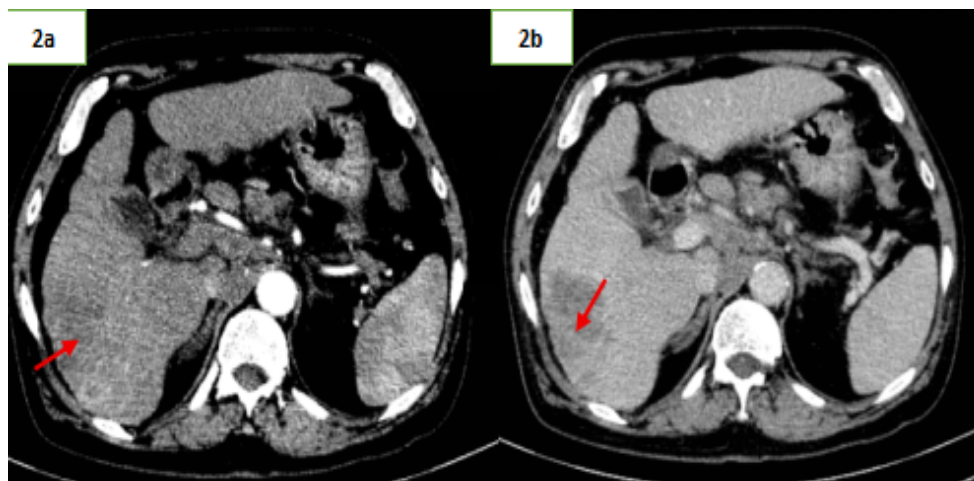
Contrast-enhanced CT (CECT) abdomen of a 50-year-old male with history of chronic alcohol use, evaluated for suspected liver lesion. Triphasic CT demonstrates a well-defined lobulated and encapsulated arterial phase-enhancing lesion with washout in the portal venous phase and delayed capsular enhancement in segment VI of the liver (red arrows), measuring 5×4 cm, characteristic of hepatocellular carcinoma.
